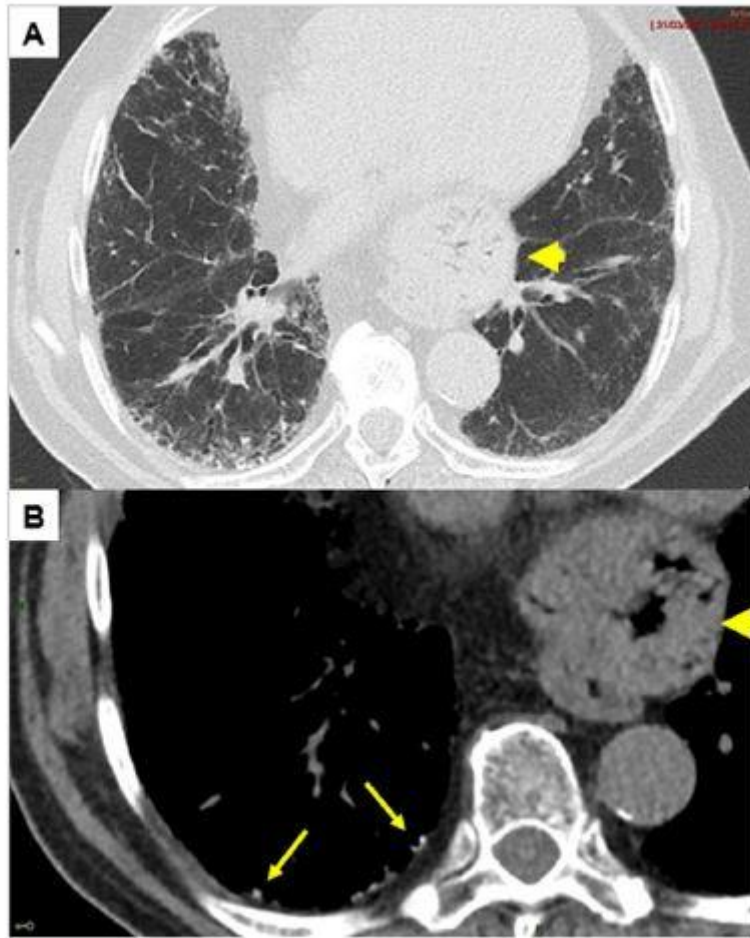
Peripheral microcalcifications (arrows) in a patient with a probable usual interstitial pneumonia pattern on the CT scan. A: parenchymal windows. B: mediastinal window. Also note a large hiatal hernia (arrowheads).
